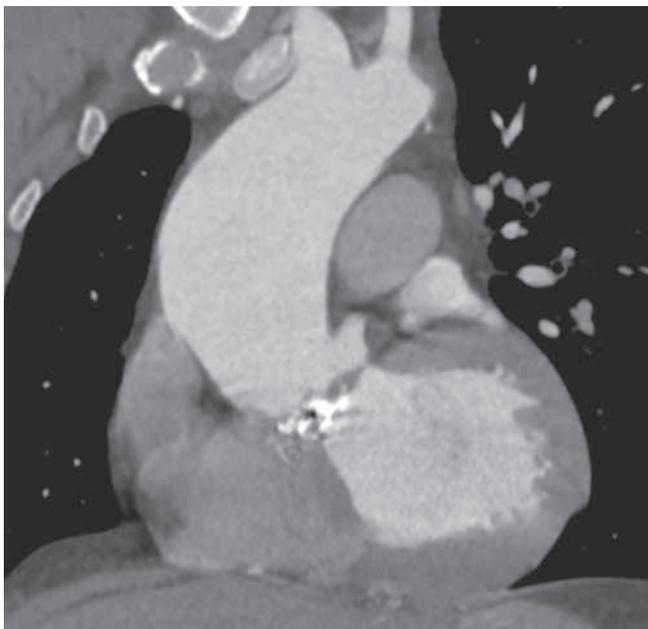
Coronal contrast-enhanced CT image demonstrating a premature degenerated bicuspid valve in a 36-year-old woman with extensive valve calcifications and thickened cusps. Note the dilated ascending aorta, a common associated finding secondary to the hemodynamic effects of aortic valve dysfunction.
